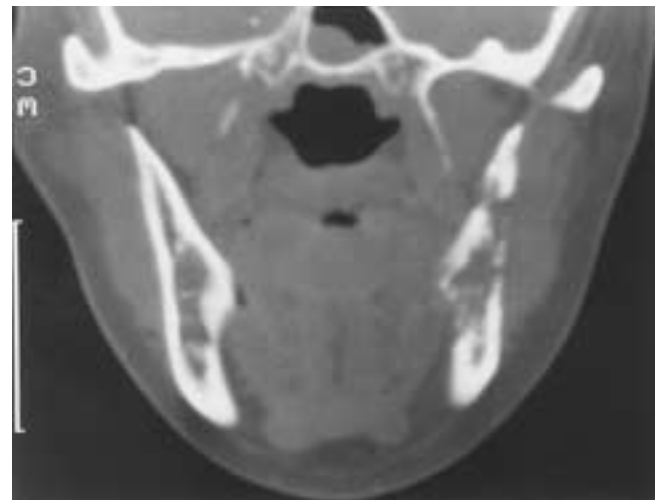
Carcinoma of the breast metastatic to the left mandible. Coronal CT through the mandible (bone window setting) shows a lytic destructive lesion in the ramus of the left mandible. There is no new bone formation.
